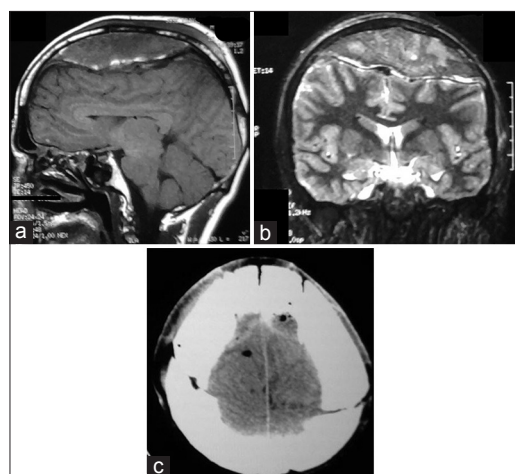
(a) Sagittal brain MRI T1-weighted identifying isointense image detaching the superior sagittal sinus. (b) Coronal brain MRI T2-weighted identifying isointense image detaching the superior sagittal sinus. (c) Brain CT showing complete evacuation of the hematoma
